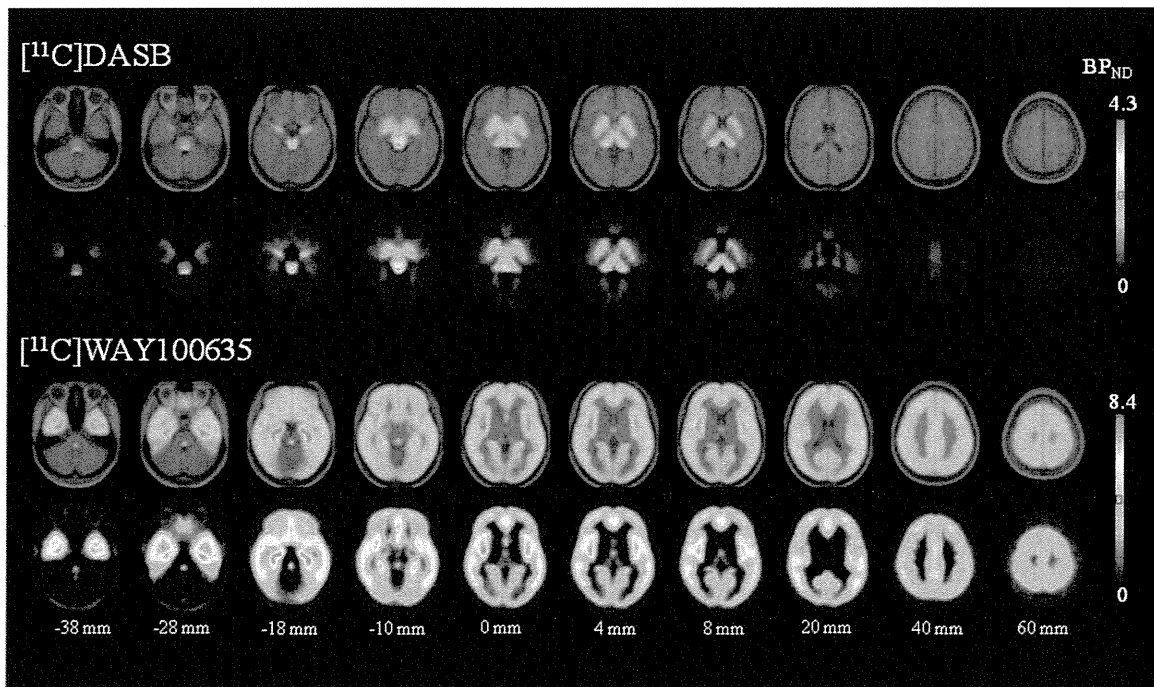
Averaged  $\text{BP}_{\text{ND}}$  images with anatomical standardization of both radiotracers (axial planes). From the top row to the bottom: fused  $[^{11}\text{C}]\text{WAY100635}$  and MRI, only  $[^{11}\text{C}]\text{WAY100635}$ , fused
